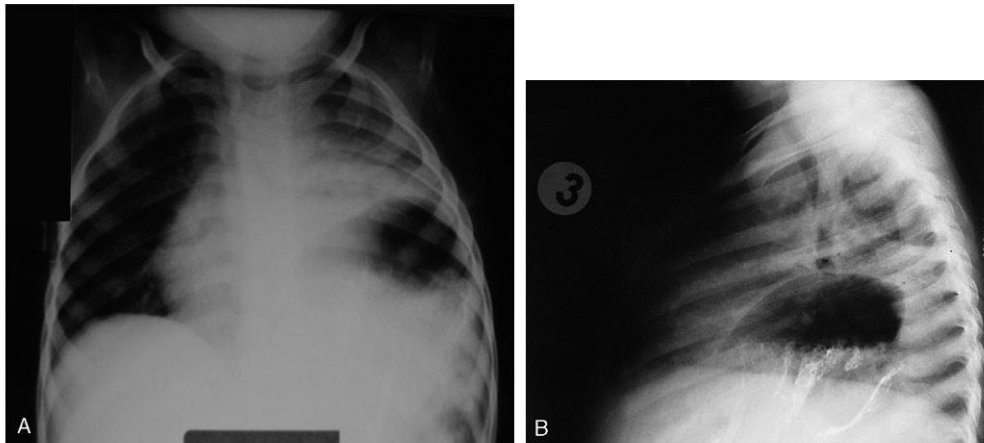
Left phrenic nerve palsy with elevated left hemidiaphragm on (A) anteroposterior and (B) lateral chest radiographs.
